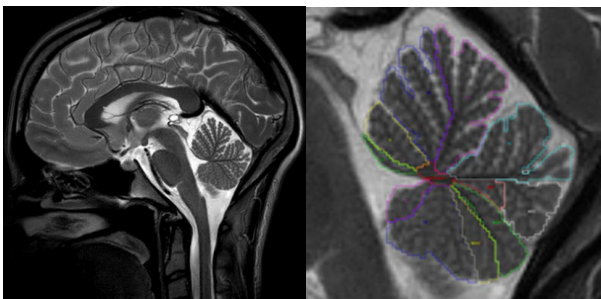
High resolution, high contrast whole head 2D T2-weighted MultiVane TSE mid-sagittal image (left) enabling a reliable segmentation of the individual cerebellar lobes (detail on the right). 48 slices were needed to cover the whole cerebellum.
